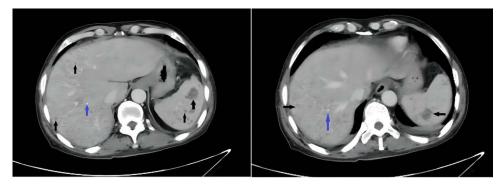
Abdominal CT reveals multiple low-density lesions in the liver and spleen (black arrows), along with multiple small calcifications (blue arrows).
